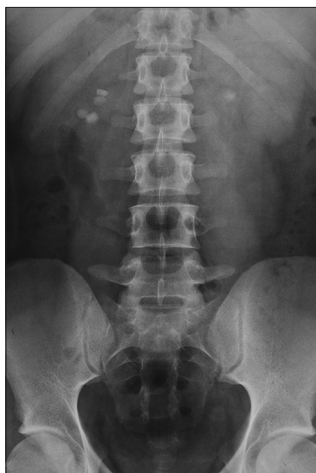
Plain X-ray of the abdomen (KUB) showing bilateral multiple radiopaque renal calculi, more in the right side
